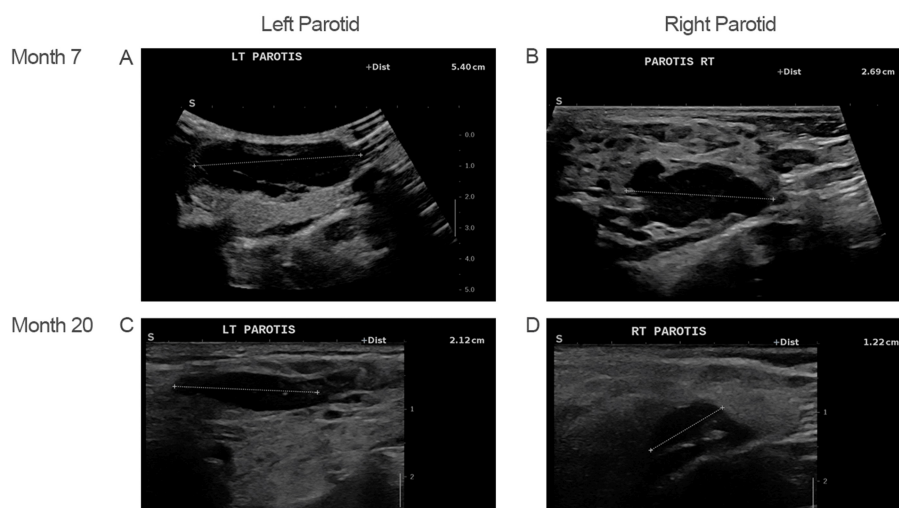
Sequential grayscale ultrasound images of the left and right parotid glands demonstrating interval reduction in lesion size.
